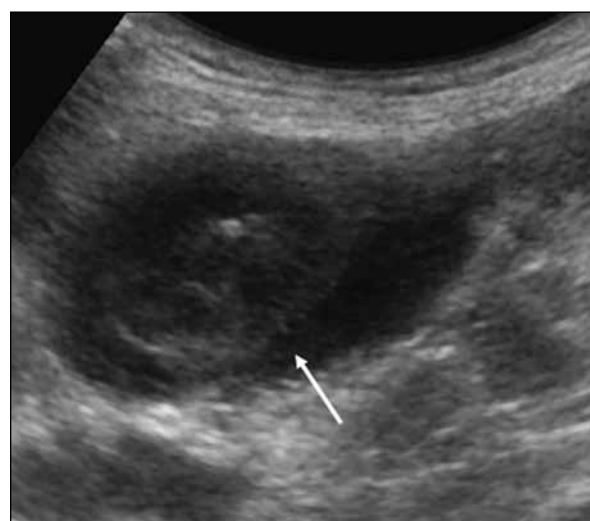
Grey-scale transabdominal ultrasound showing mild diffuse thickening of the small bowel loops (arrow)
